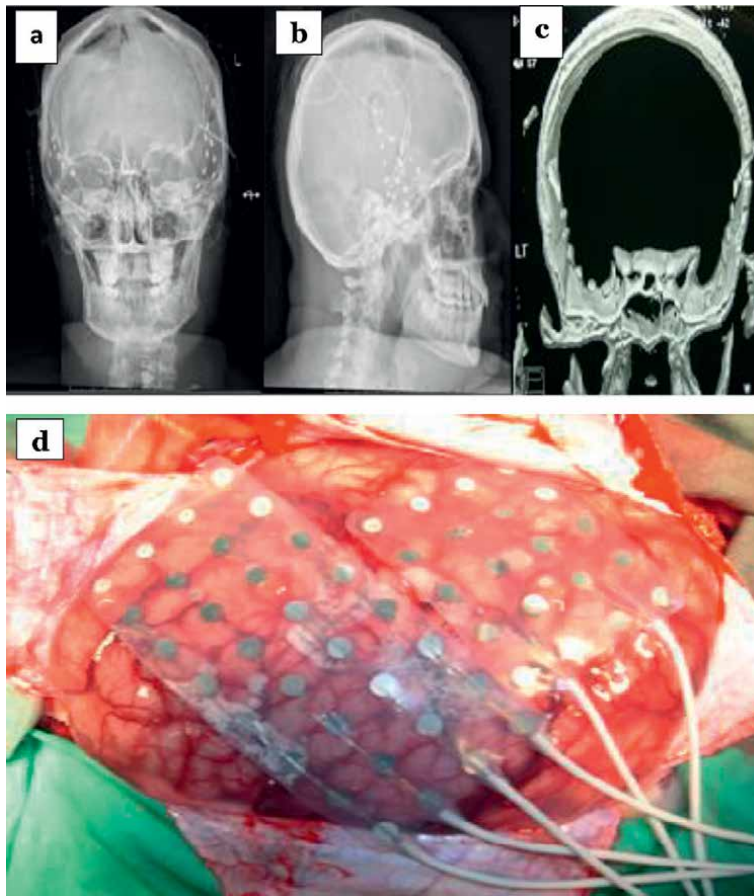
Intracranial monitoring; a & b; skull x-ray images, showing temporal bilateral intracranial strip electrodes, c; brain CT, axial cut, bone window technique, showing bilateral temporal intracranial electrodes. And d; intraoperative view showing over the brain cortex, 2 grids (4x8 & 4x5 electrodes).
